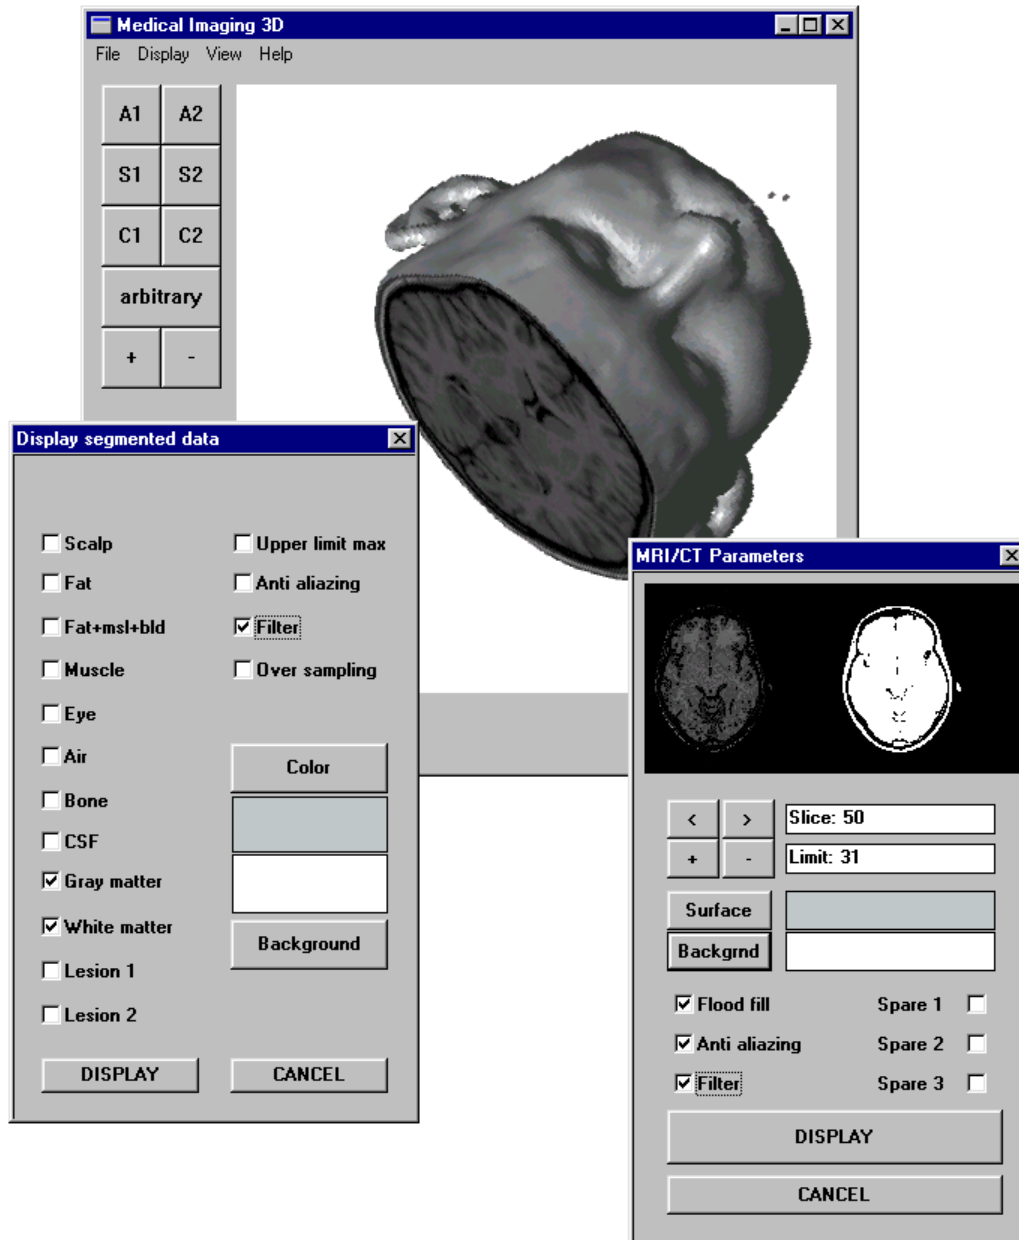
The user interface of the Medimag™ 3D software. The generated 3D image is presented on the main window, which enables definition of projection planes, zoom factor, sections, etc. If the source data consist of raw information like the original CT or MR images, the "MRI/CT parameters" window appears and requires threshold coefficients, surface and background colors and some additional parameters for displaying the images. If the source data are preprocessed (segmented), the display-segmented window appears, by means of which appropriate tissues are then displayed.
